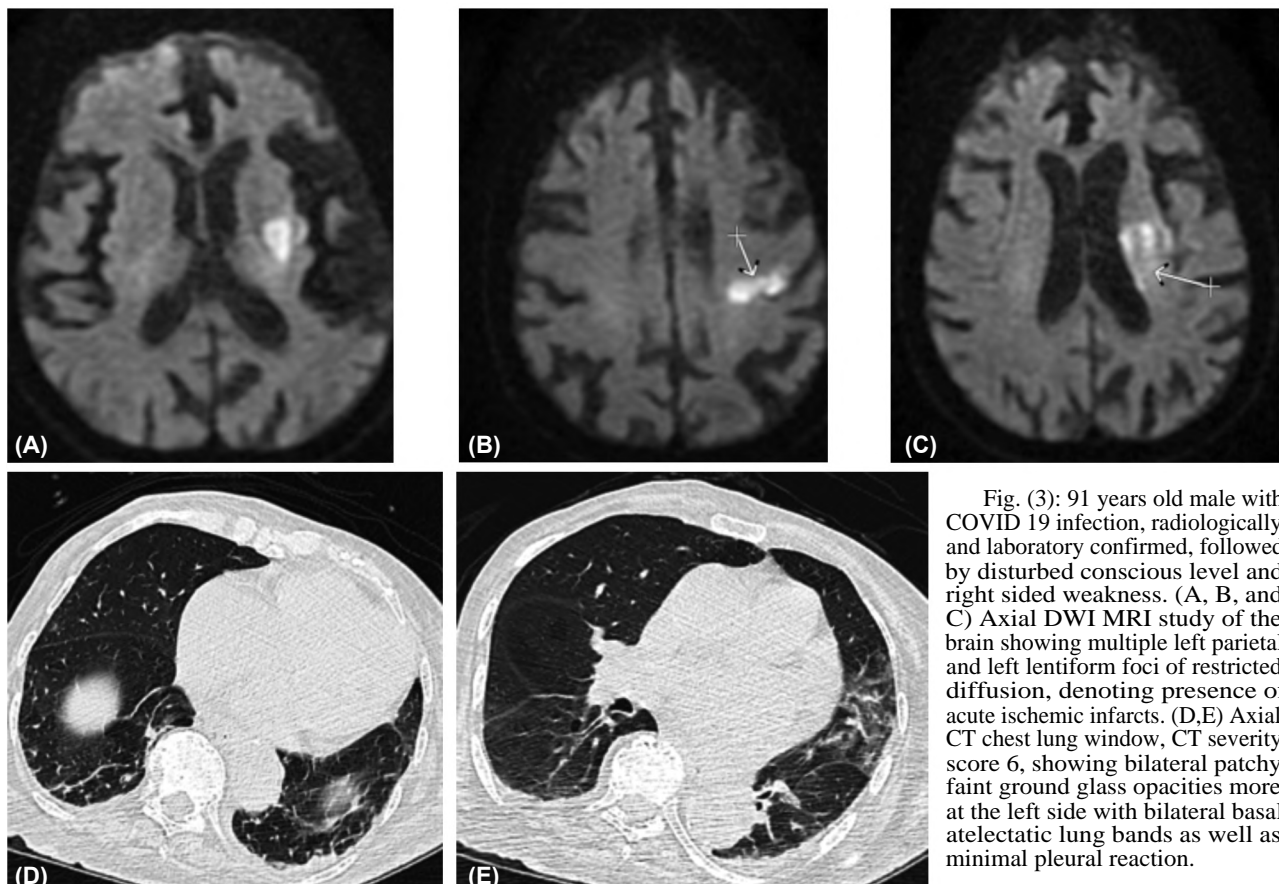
91 years old male with COVID 19 infection, radiologically and laboratory confirmed, followed by disturbed conscious level and right sided weakness. (A, B, and C) Axial DWI MRI study of the brain showing multiple left parietal and left lentiform foci of restricted diffusion, denoting presence of acute ischemic infarcts. (D,E) Axial CT chest lung window, CT severity score 6, showing bilateral patchy faint ground glass opacities more at the left side with bilateral basal atelectatic lung bands as well as minimal pleural reaction.
